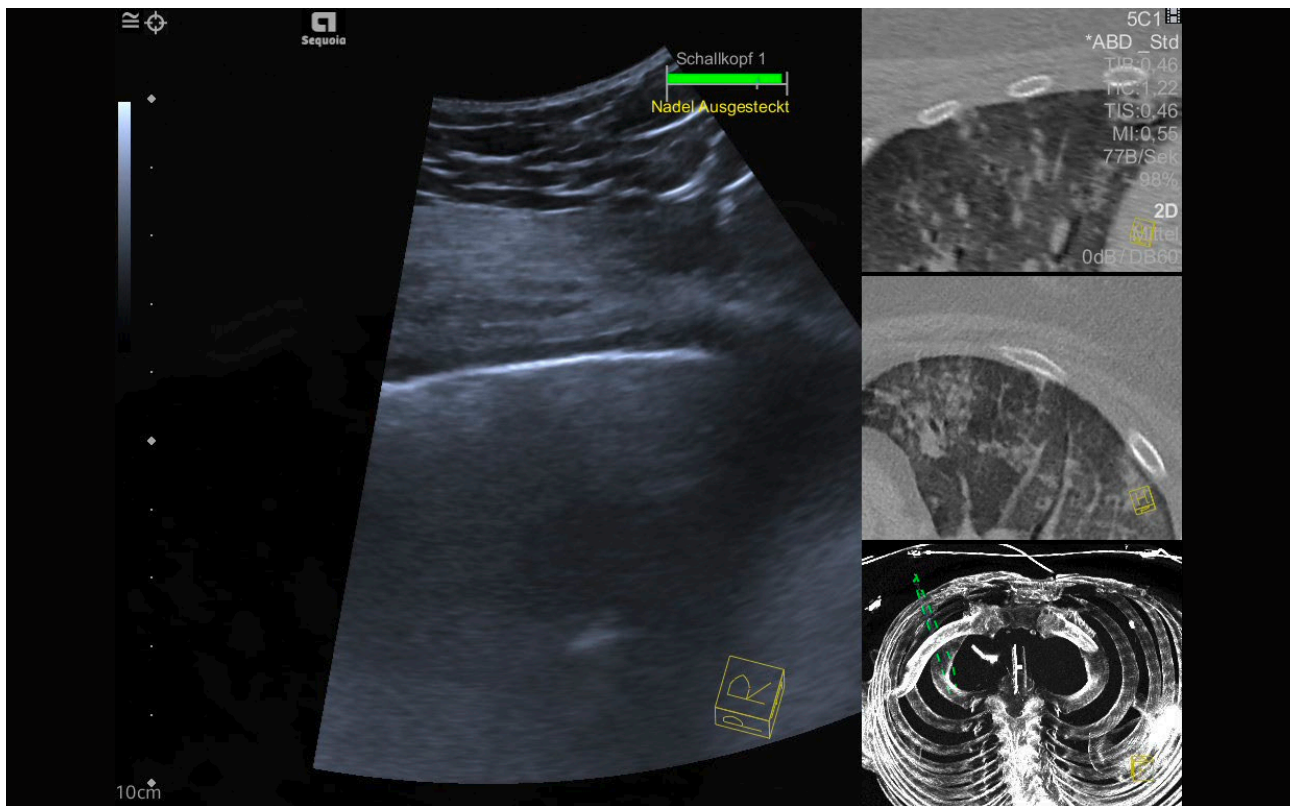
COVID-19 pneumonia. Follow-up examination in the ICU using real-time image fusion technique with a curved transducer. Ultrasound findings including pleural thickening and consolidations of the lung in the side-by-side mode are detected. HR-CT showed ground glass opacity and reticular shadows under the pleura in the field of the right lung.
